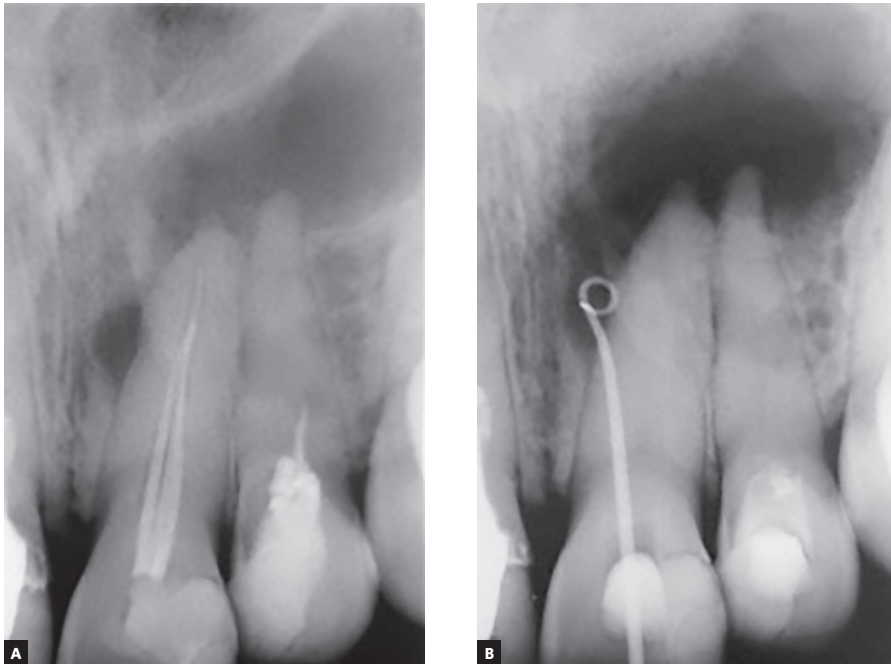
A) Initial radiograph. B) Tracking the fistula on tooth #21.
